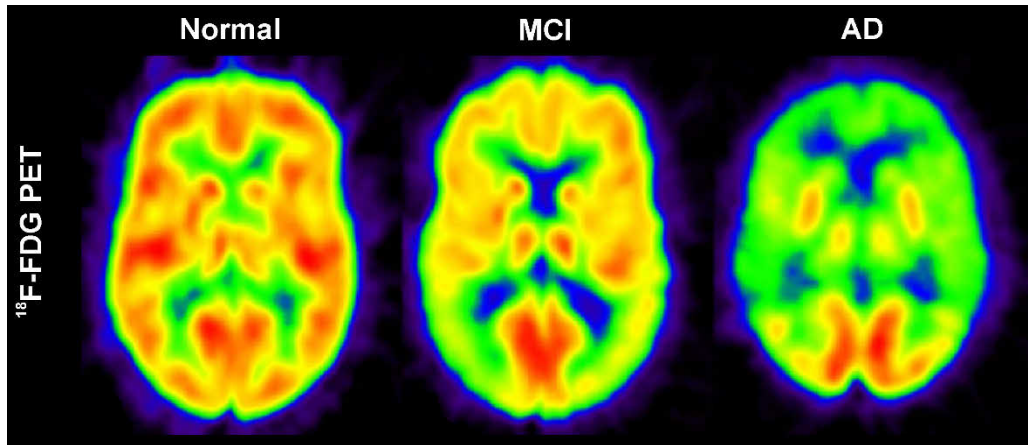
Changes in cerebral ^{18}F -FDG retention in a dementia continuum. A cognitively asymptomatic (normal) individual (*left*) has greater tracer retention in the brain compared to an individual with mild cognitive impairment (MCI; *center*). Decreases in the ^{18}F -FDG retention can be detected in the posterior cingulate cortex at early disease stage. In a patient with diagnosed Alzheimer's disease (AD) dementia (*right*), the ^{18}F -FDG retention has further declined in the bilateral temporo-parietal and frontal lobes, and basal ganglia compared to individual with MCI. Modified from Rice and Bisdas 2017.
